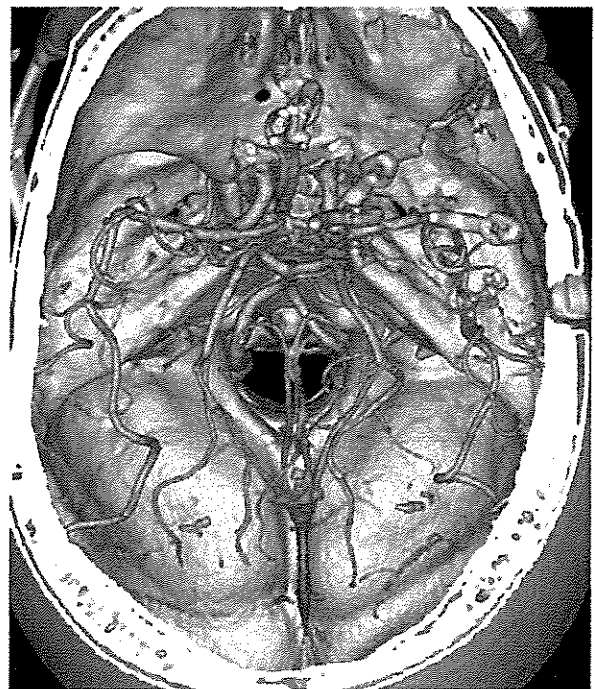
Postoperative CT angiogram (volume rendered reconstruction) shows multifocal aneurysmal clips in situ on the left, with no residual aneurysmal filling
